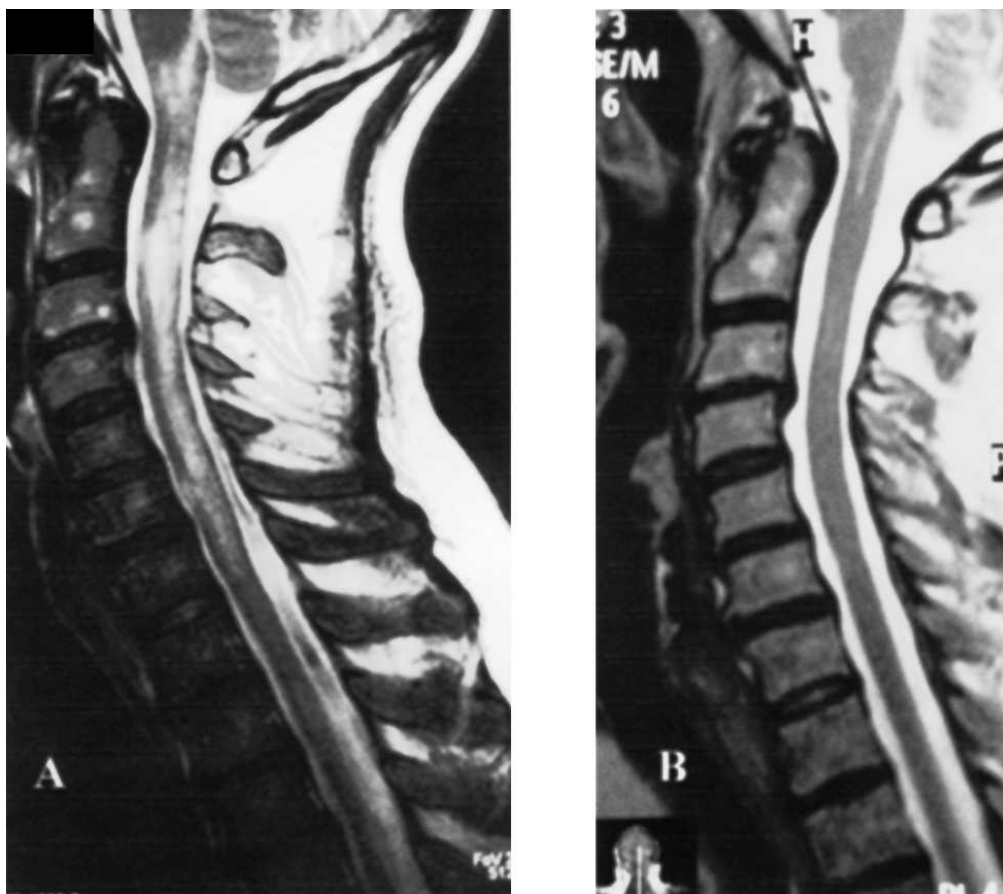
(A) MRI scan of the cervical cord. Sagittal T2-weighted image showing increased signal intensity of the cervical spinal cord and lower brainstem. (B) Sagittal T2-weighted image 2.5 years later; normal signal intensity.
